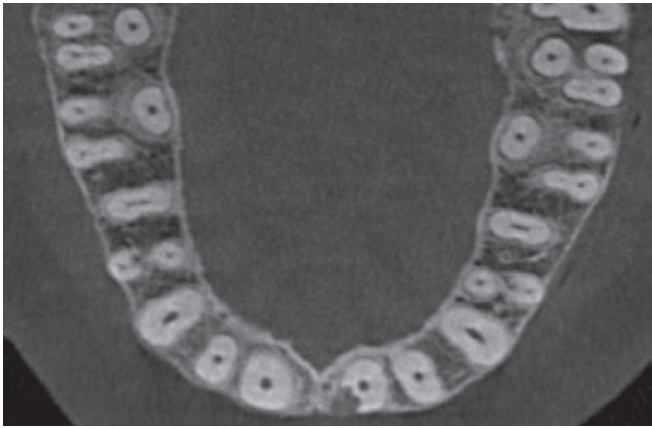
CBCT axial section showing all maxillary teeth with bilateral symmetry in number of roots and number of canals
